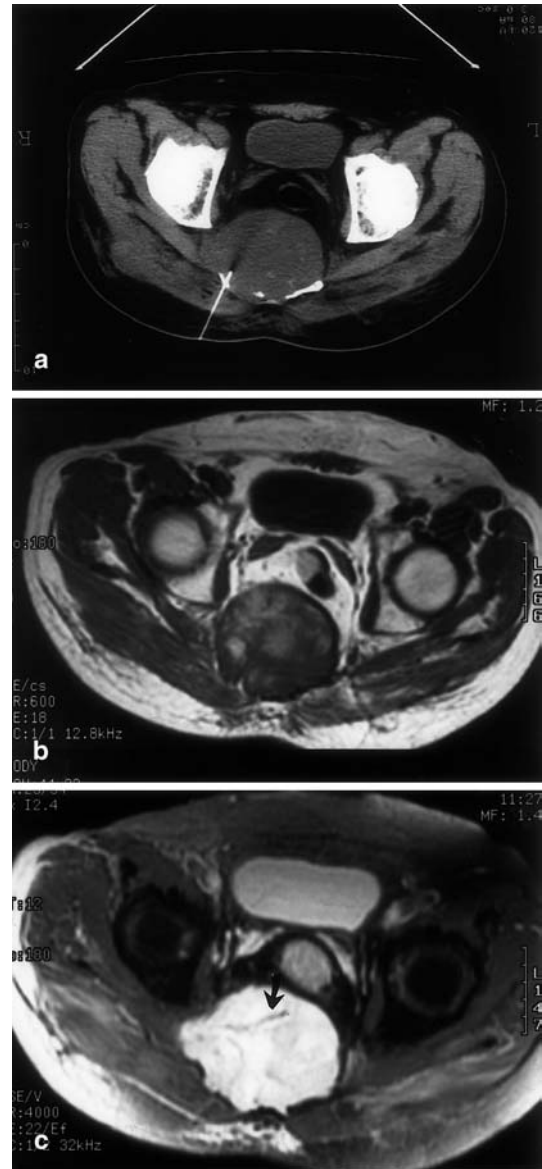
Chordoma of the sacrum. a The CT scan shows a large destructive lesion of the sacrum with soft tissue density and internal foci of calcifications. Note the needle of biopsy which establishes the diagnosis. b Axial T1-weighted image shows a well-margined sacrococcygeal lesion with interspersed high-signal areas. c Axial T2-weighted image shows high signal intensity mass with internal low signal septae (*arrow*)
